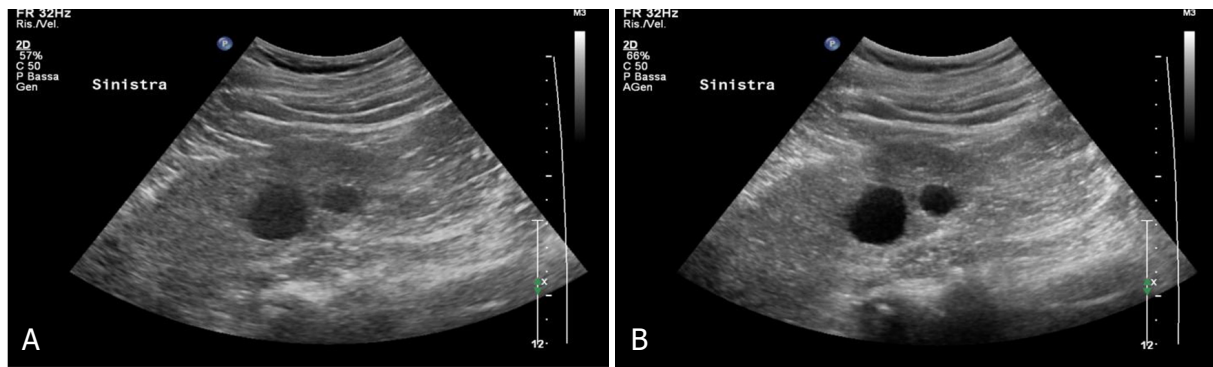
Simple cyst. A: Greyscale sonograms of the left kidney shows hypoechoic round lesion with smooth margins without perceptible wall; B: Tissue harmonic imaging may be useful to show better the posterior acoustic
